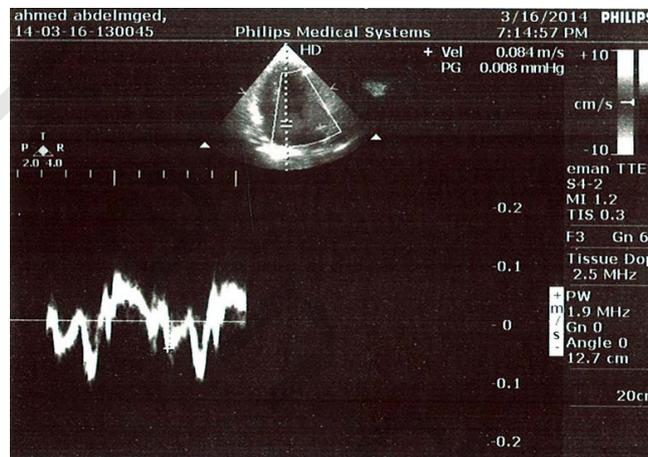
Tissue Doppler mitral annular velocity after dialysis.
